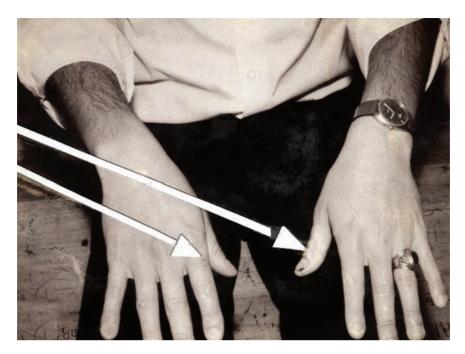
HANDS OF THE SUSPECT. Both hands of this suspect, who has been charged with homicide, show evidence of a violent struggle, as indicated by the arrows, and are actually part of the crime scene. These photos should be taken in black-and-white and color, with a marker. (From the author's files.)
